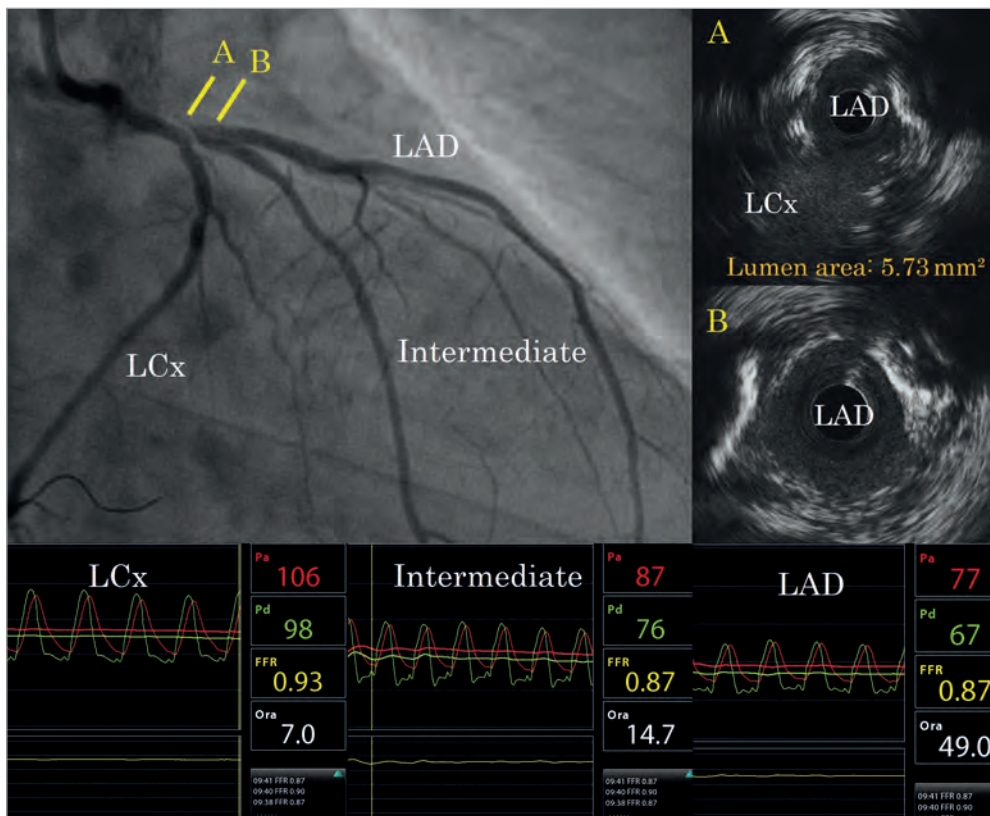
The results of FFR and IVUS measurements. FFR value was 0.87 in the left anterior descending (LAD) and intermediate arteries and 0.97 in the left circumflex. IVUS revealed jailed BVS struts with a minimum lumen area of 5.73 mm² at the carina site (A) and lumen area of 5.96 mm² distal to the carina site (B). BVS: bioresorbable vascular scaffold; FFR: fractional flow reserve; IVUS: intravascular ultrasound
